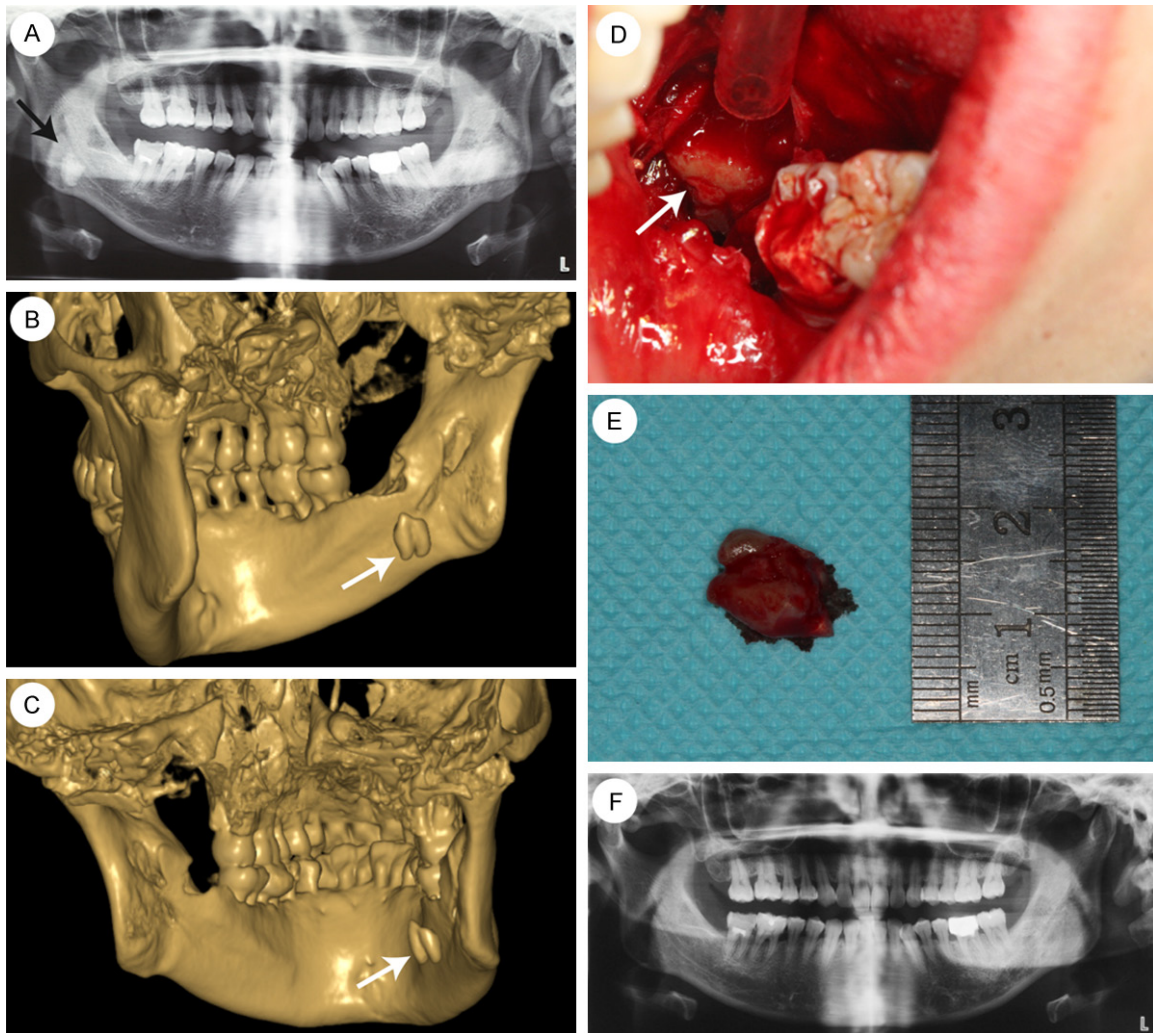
Case 2: A 33 year old female with displaced mandibular third molar root. A. Panoramic x-ray showed remnants of some fragments on the mesial side, below and behind the lingual tooth socket. B and C. CBCT images showing the location of the displaced root in the sublingual space. D. Intraoral view showing reflection of the flap to expose the area. The lingual nerve and the flap are in close proximity. E. The displaced tooth/root fragment was removed from the patient's mouth. F. Postoperative panoramic x-ray of the patient.
